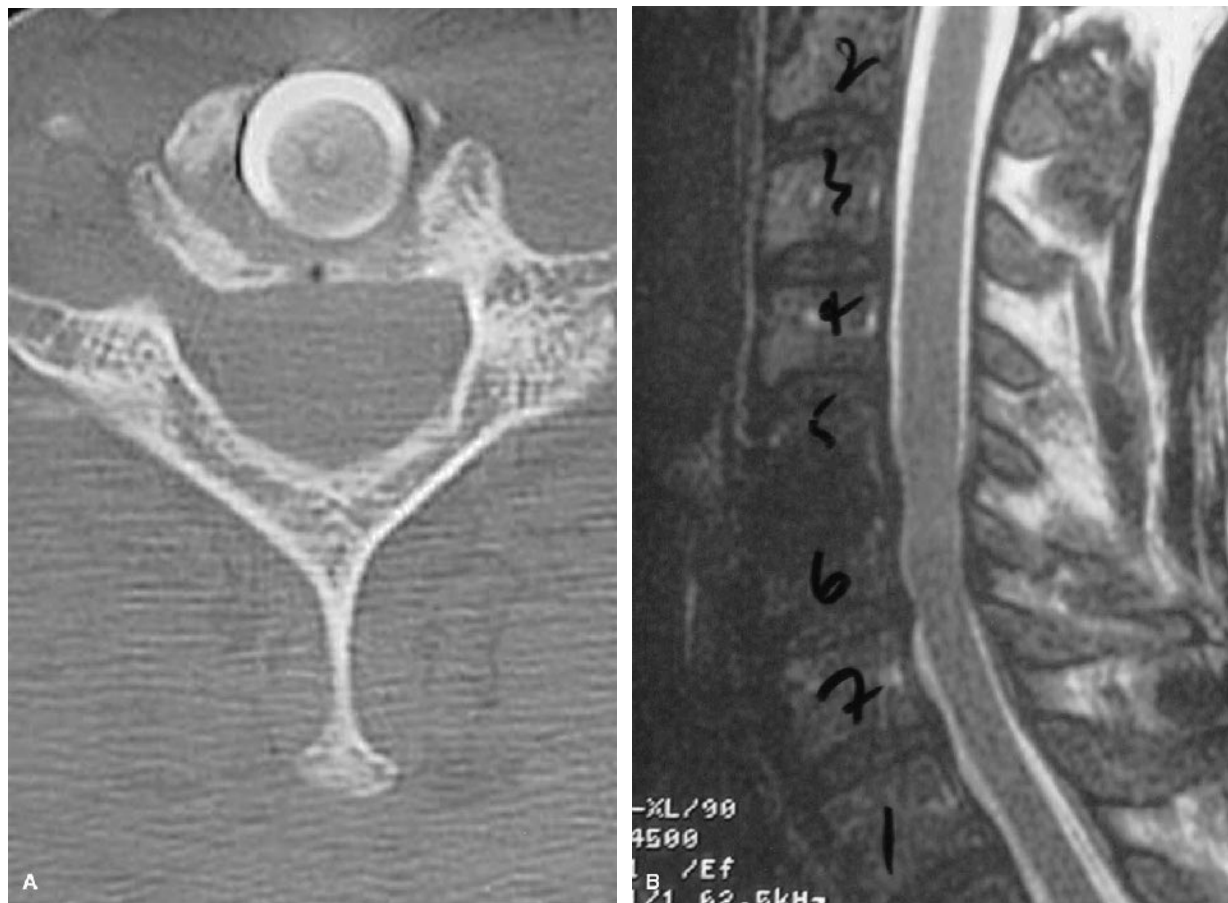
Postoperative axial CT scan (A) and sagittal MR scan (B), showing the artificial disc prosthesis after surgery in case 3. On the CT, it is evident that the prosthesis occupies most of the space previously occupied by the intervertebral disc. The MR reveals that the titanium shells do cause artifact with this modality, but the canal is still able to be visualized. This was not the case in every postoperative MR scan.
